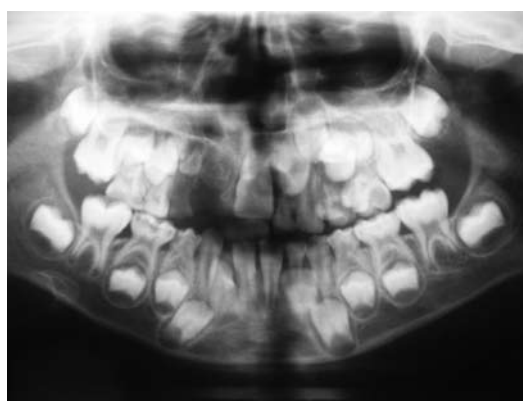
Panoramic radiograph shows the teeth with 'ghost-like' appearance in maxillary right quadrant. All teeth are normal except in the right maxillary quadrant.
